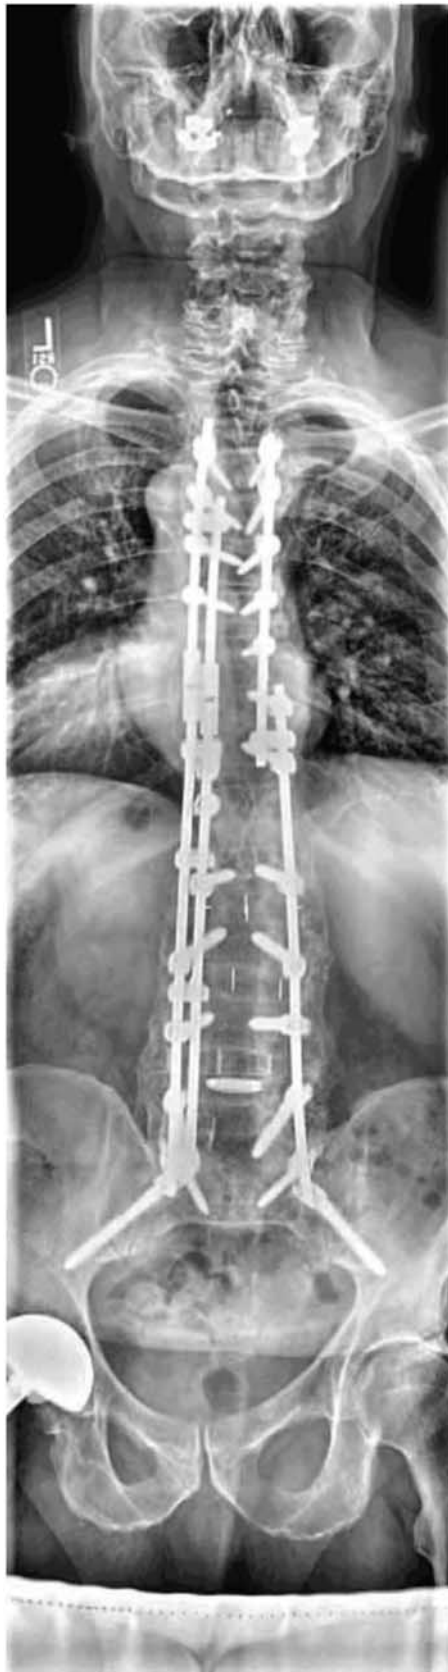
Three years postoperative radiographs demonstrating a left S2 iliac screw fracture within the middle of the shank.
